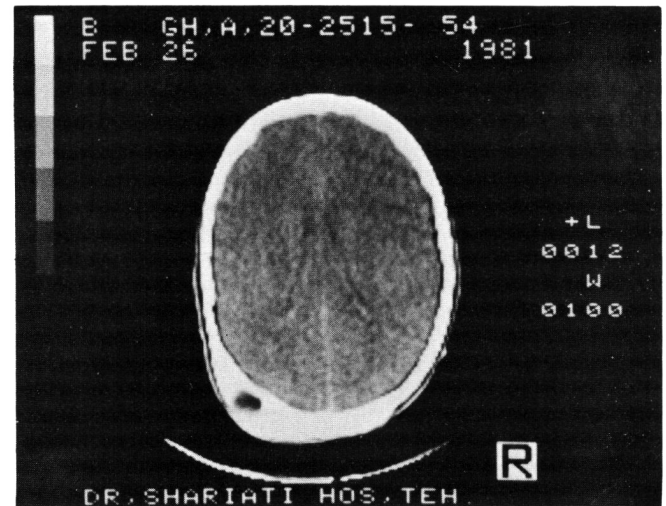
CT scan (with enhancement) of case 4, shows a dense lesion of the bone extending beyond the midline with one small cavity containing low density fluid.
